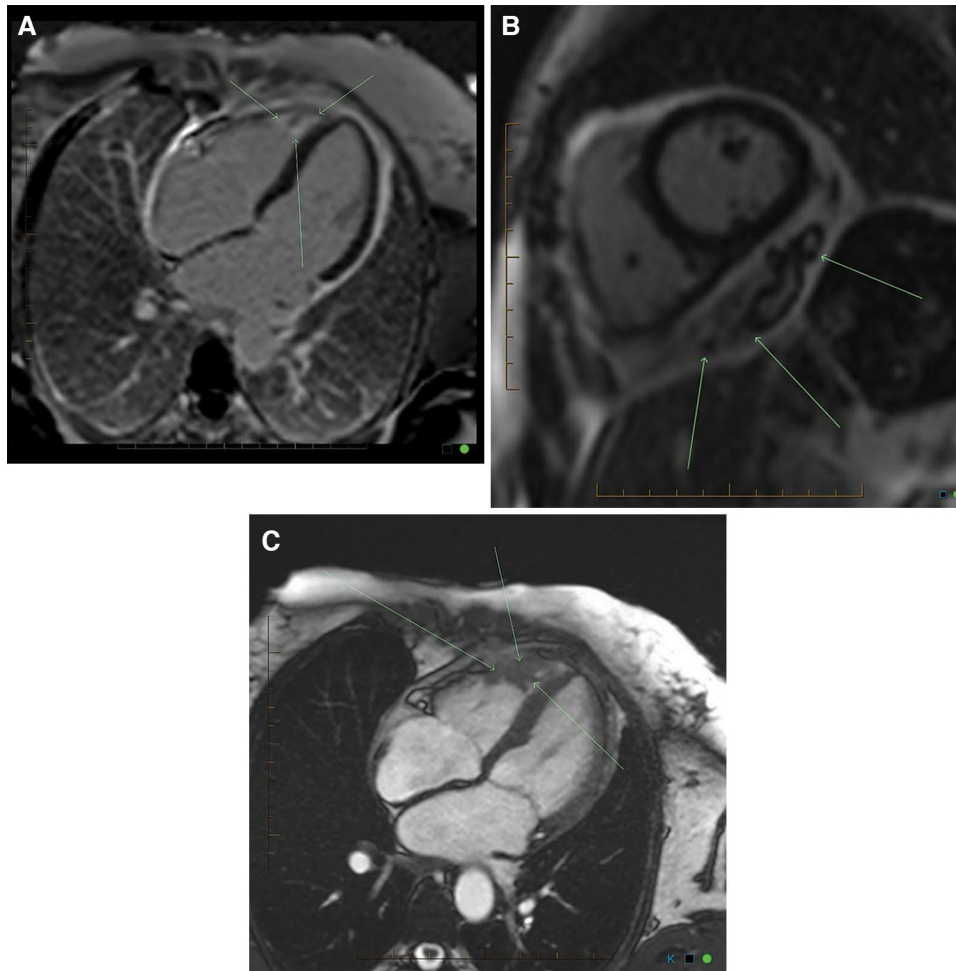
(A) Axial cardiac magnetic resonance imaging view with late gadolinium enhancement at the right ventricular apex and pericardium post-four cycles of induction immunotherapy. (B) Short-axis oblique views on magnetic resonance imaging with late gadolinium enhancement and heterogeneity of the pericardial tumour post-four cycles of induction immunotherapy. (C) Axial cardiac magnetic resonance imaging steady-state free precession view demonstrating right ventricular filling defect post-four cycles of induction immunotherapy.
